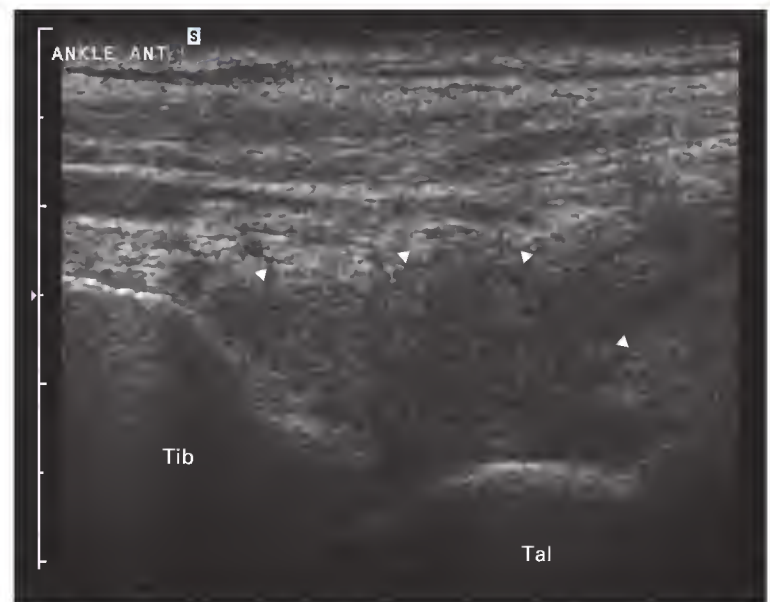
Sonogram taken longitudinally across the anterior ankle joint. There is severe synovitis filling the anterior joint space (arrowheads). Tal, talus; Tib, tibia.
